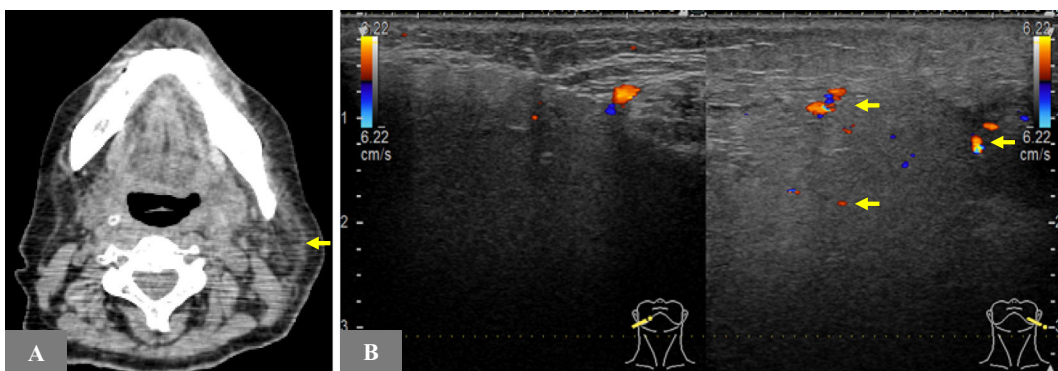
Images of parotitis on computed tomography (A) and ultrasonography (B) before the fourth administration of L-asparaginase, on day 16. The enlarged left parotid gland is apparent on computed tomography (A). Thickening and increased blood flow of the left parotid gland are detected on ultrasonography (B).
